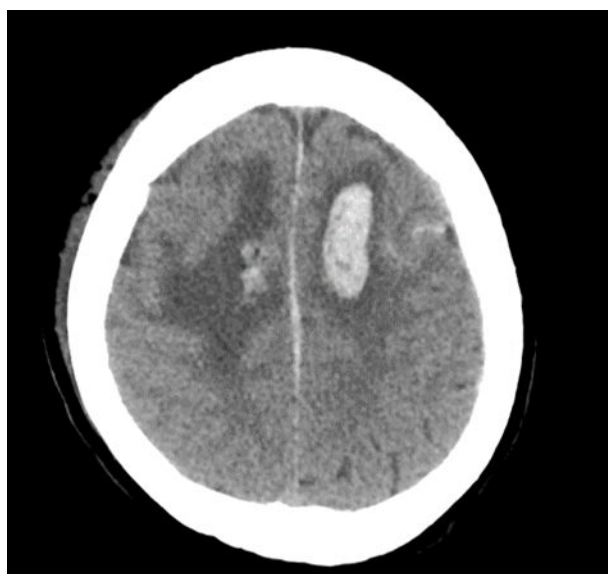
CT brain-Post-op Day 1.
